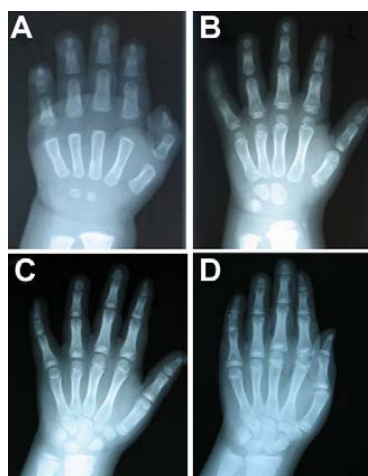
Radiographs of the left hand at different ages. (a) Radiograph at the age of 1 year shows short distal phalanges in fingers II–V. The shape of the third and fourth distal phalanx resembles an inverted triangle. Punctate calcifications are not seen. (b) At the age of 5 years mainly the distal phalanges of third and fourth finger are short and dysplastic. The epiphysis seems to be attached to the body of the phalanx that still has an inverted triangle shape. (c) The distal phalanges of third and fourth finger remain small at the age of 9 years due to premature closure of the growth plate. There is also mild shortening of the distal phalanx of second finger and middle phalanx of fifth finger. (d) Similar findings are found on the radiograph taken at the age of 12 years.
